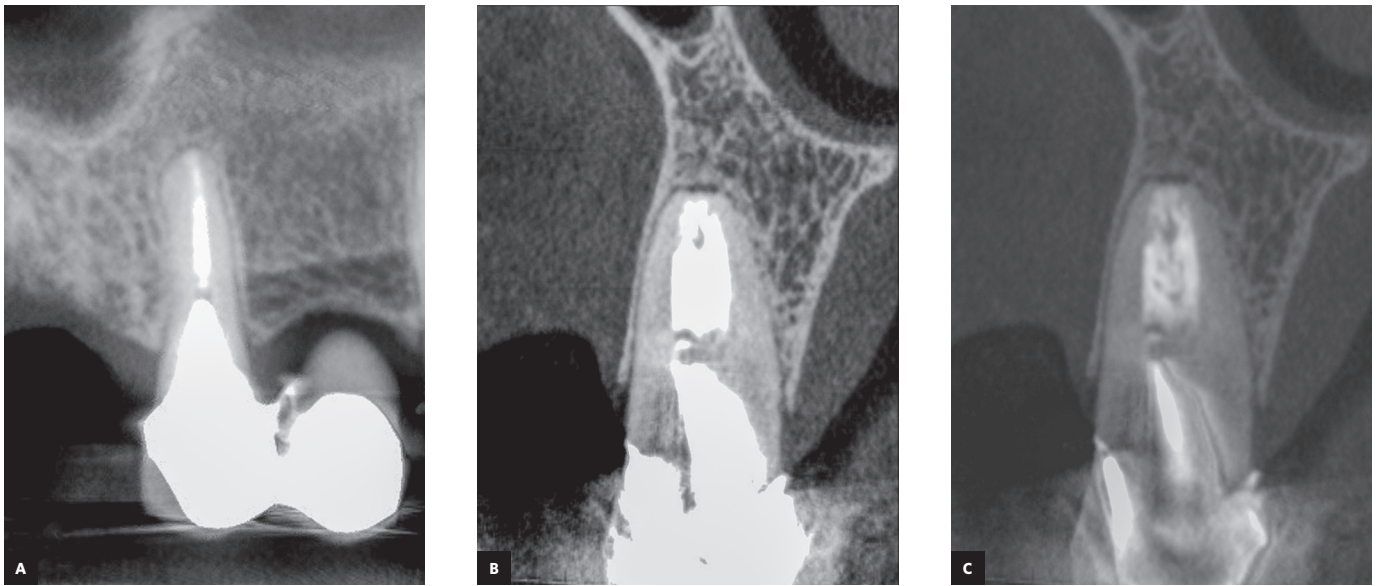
(A, B) CBCT scans show white contrast artifact in the intraradicular post in tooth #11, and its remotion after the use of the CBCT e-Vol DX software, characterizing the space between the post and the walls of the root canal (C).
